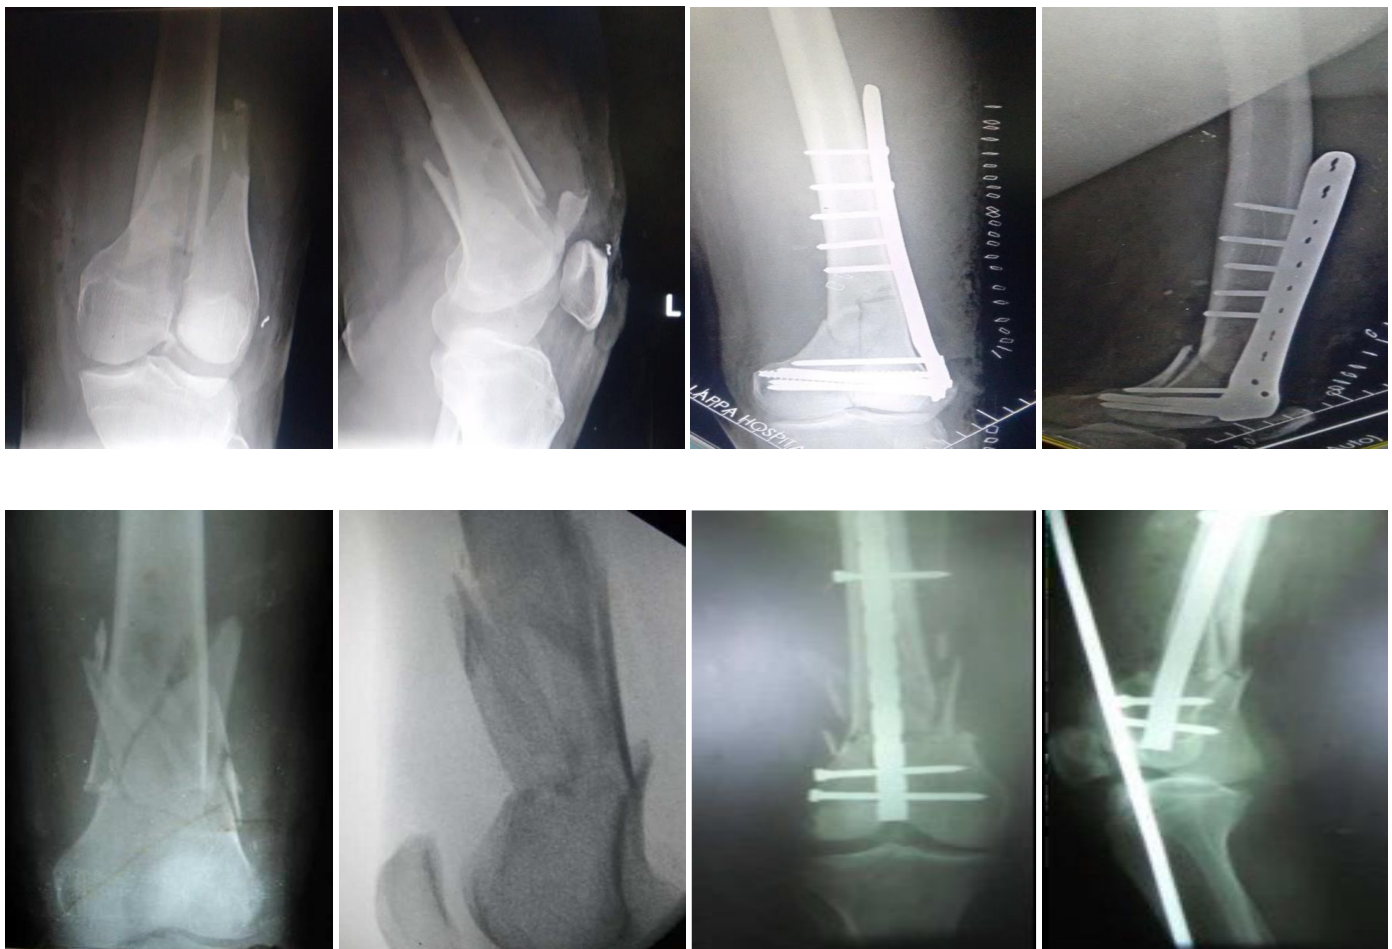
Pre Op and Post Op x-rays of the patients.
